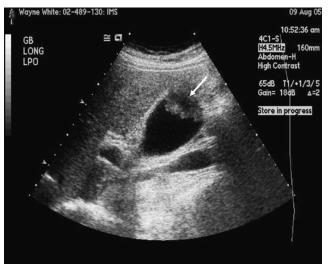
Ultrasonographic finding of gallbladder cancer (*white arrow*).
